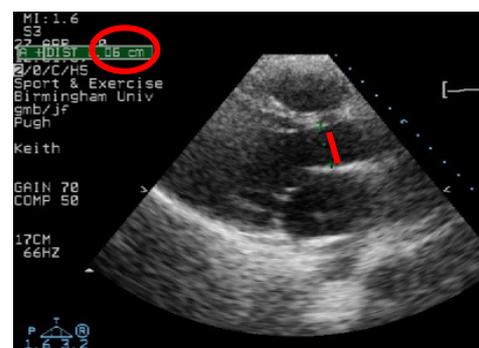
Parasternal view. Red line represents the cross-sectional area of the aortic orifice. Red circle shows the calculated value of cross-sectional area.
